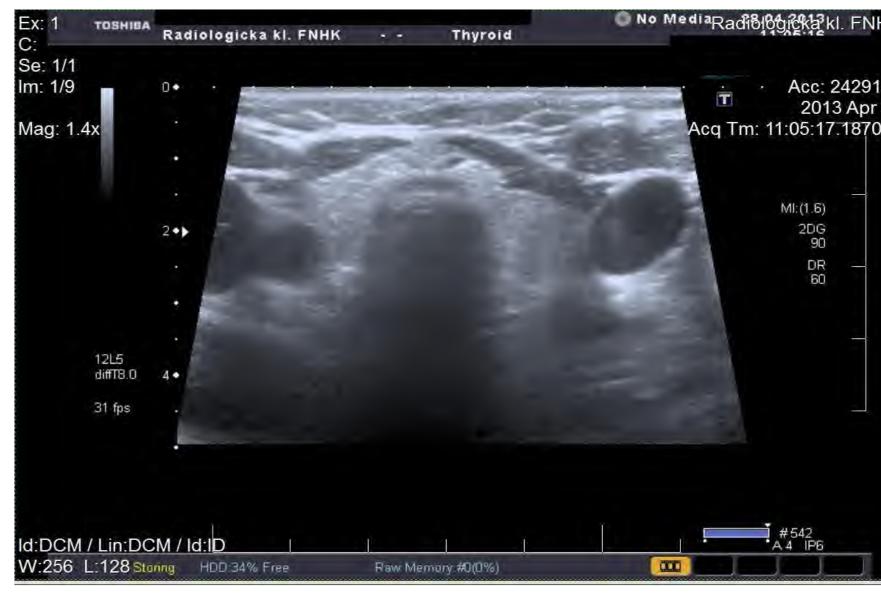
Ultrasonography of thyroid and parathyroid glands
